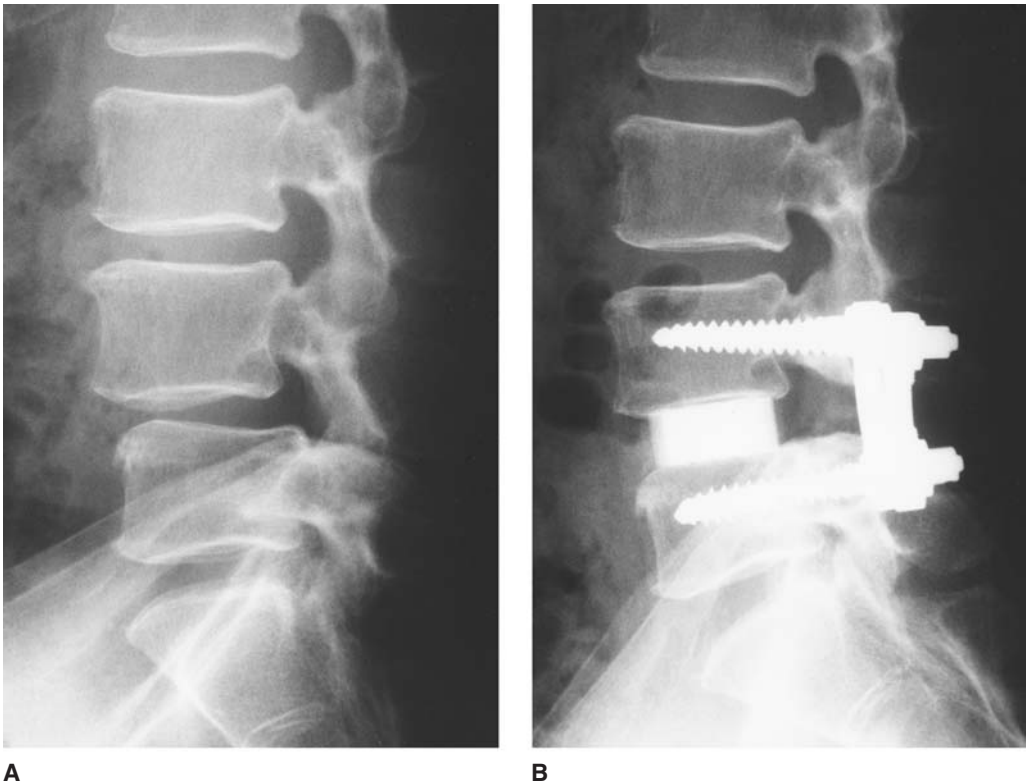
Lateral radiographs in a 63-year-old man with degenerative spondylolisthesis in L4–5 obtained before surgery (A), one year after surgery (B), and 5 years after surgery (C). Posterior lumbar interbody fusion was performed with the AW-GC intervertebral spacer and the Akita Pedicle Screw System. Bone union (trabecular bony bridging) was observed by time. No radiolucent zones around the AW-GC spacer and pedicle screws were seen.
